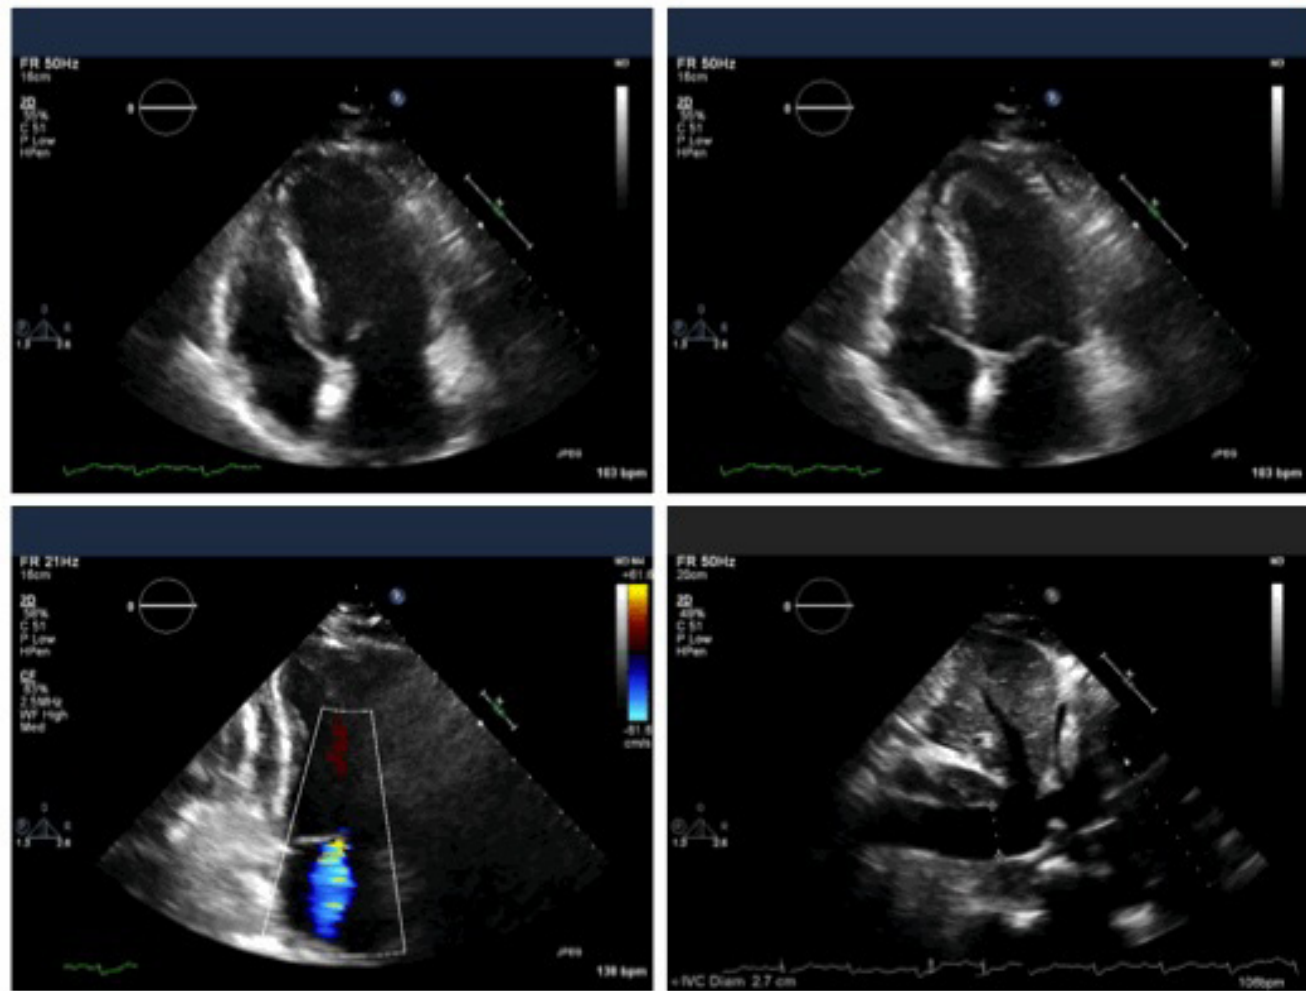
Transthoracic echocardiogram at initial presentation showing a small, predominantly posterior and inferior pericardial effusion; mildly reduced left ventricular systolic function with an estimated ejection fraction, and a dilated inferior vena cava. End-diastolic apical 4-chamber view (left upper); End-systolic apical 4-chamber view (right upper); Apical 2-chamber view (left lower); subcostal view of the inferior vena cava (right lower).
